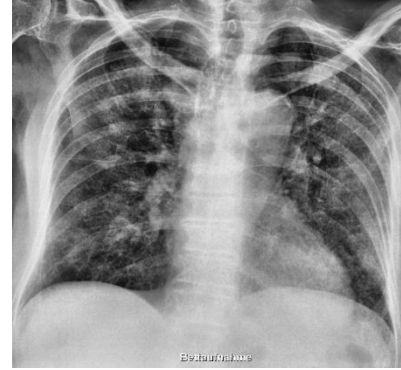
COVID-19 CHEST X-RAY
